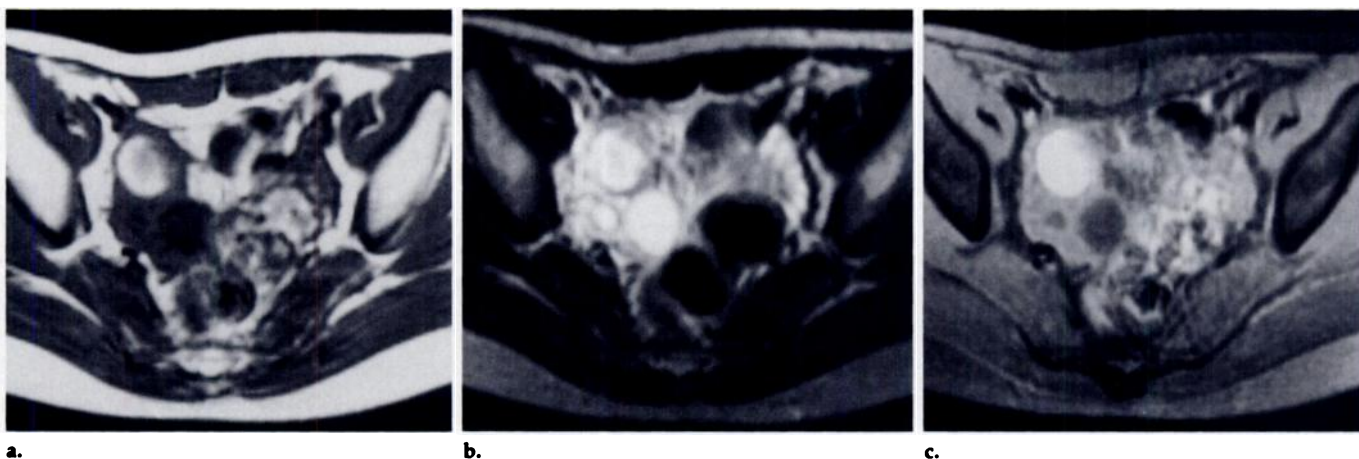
(a) T1-weighted (600/15), (b) T2-weighted (2,000/80), and (c) fat-saturated T1-weighted (600/15) MR images obtained in a 24-year-old woman in whom hematosalpingitis was identified at surgery. The right adnexal cyst exhibits high signal intensity on the fat-saturated image and mimics an endometrial cyst. Surgery revealed hematosalpingitis of the right adnexa.
